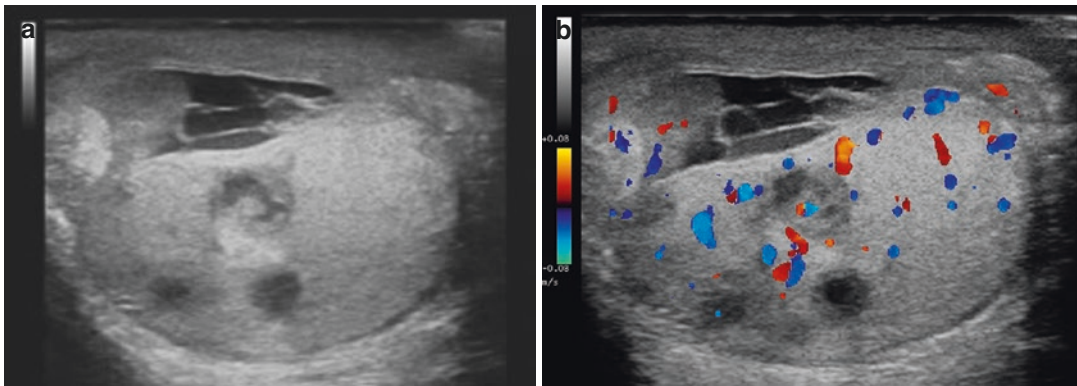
(a, b) Patient with epididymo-orchitis after BCG not responding to therapy. (a) Transverse US image shows focal heterogeneous parenchymal echotexture areas in the testis. (b) The colour Doppler image demonstrates absence of flow within the lesion and surrounding increased flow
